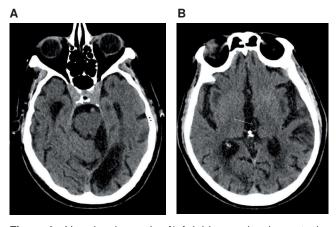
Vascular dementia. A) Axial image showing a stroke in the left posterior cerebral artery. B) Axial CT scan that shows an infarct in the medial thalamus (arrow). This lesion by itself is responsible for clinical cognitive impairment.
